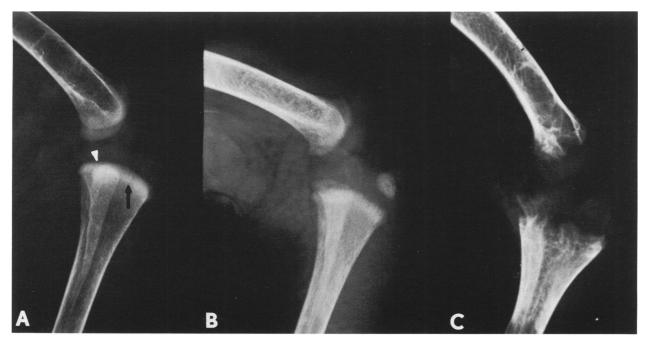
Lateral radiograph of knee in chicks given supplements of 1α ,25-dihydroxyvitamin D₃ (A, 3 days after fracture; B, 22 days after fracture; and chicks withdrawn from 1α ,25-dihydroxyvitamin D₃ (C, 22 days after fracture). A—No rachitic changes are identified. Note the excellent mineralization of the bony trabeculations subjacent to the cartilaginous growth plate (*arrows*). The delineation of these trabeculations from the growth plate is sharp (*arrowhead*). B—Mild rickets is demonstrated by a decrease in the mineralization and number of bony trabeculations beneath the growth plate. The interface between the cartilaginous growth plate and the trabeculations is irregular. C—Advanced rachitic changes. Note widening of growth plate in transaxial dimension and slight concave configuration.
